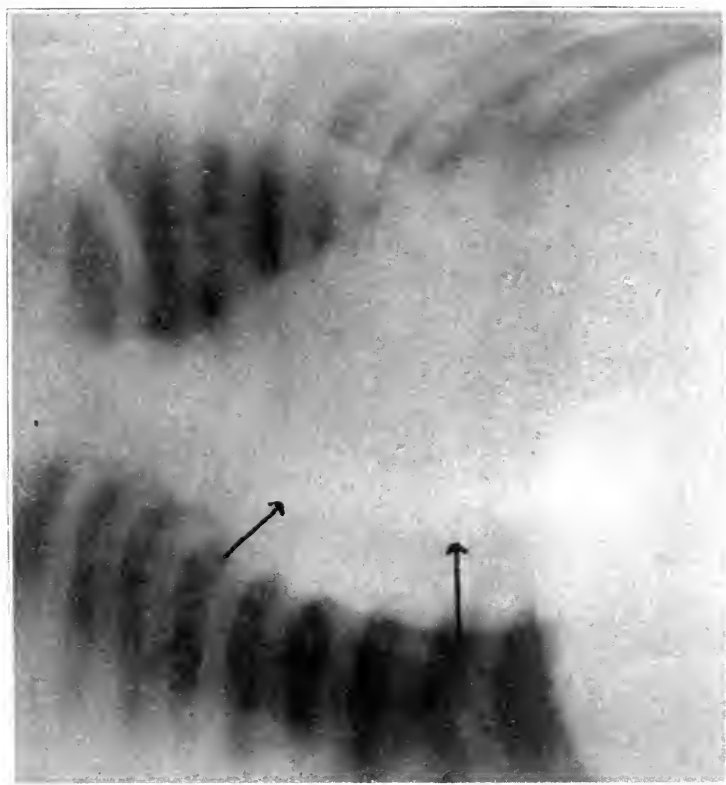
Roentgenogram of patient suffering from lateral curvature of the spine, the convexity to the left. Note apparent enlargement of the heart. Closer observation shows this only apparent as the spine curves around to the right of the heart shadow. Note increased intercostal spaces on the right and decreased intercostal spaces on the left.
